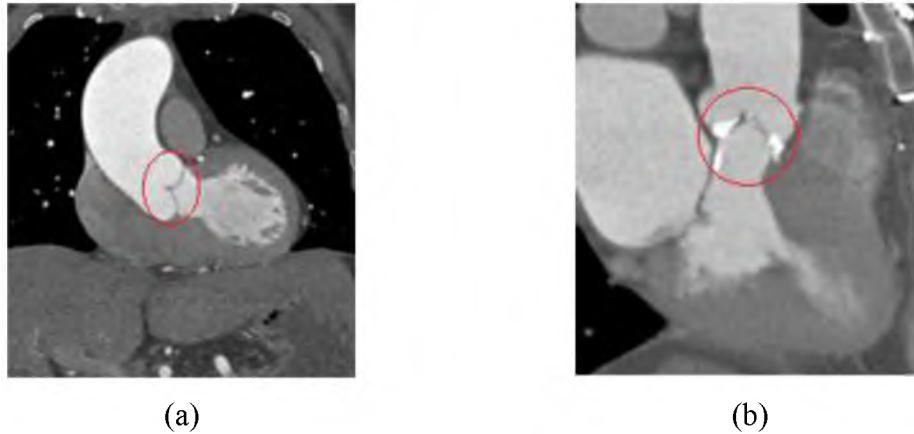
(a) Normal and (b) abnormal aortic valve in CT scan image.
